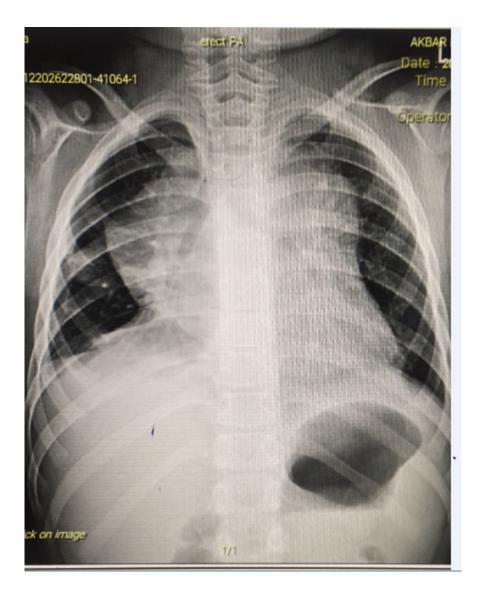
The patient's chest radiograph demonstrating a mediastinal widening, suggestive of mediastinal mass
